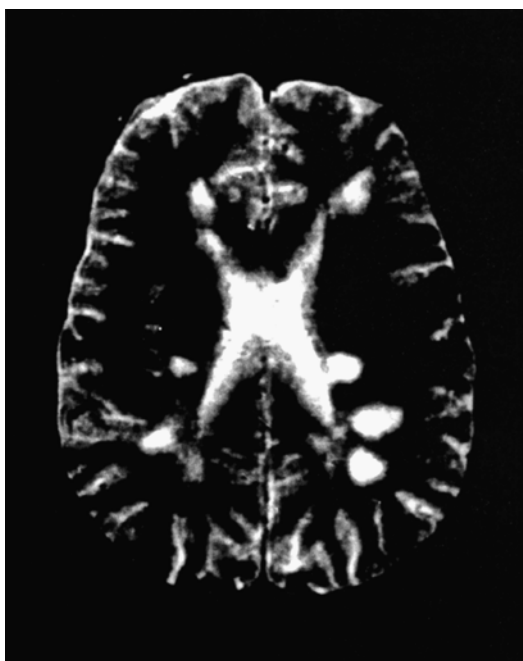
T₂ weighted MRI shows hyperintense white matter foci
